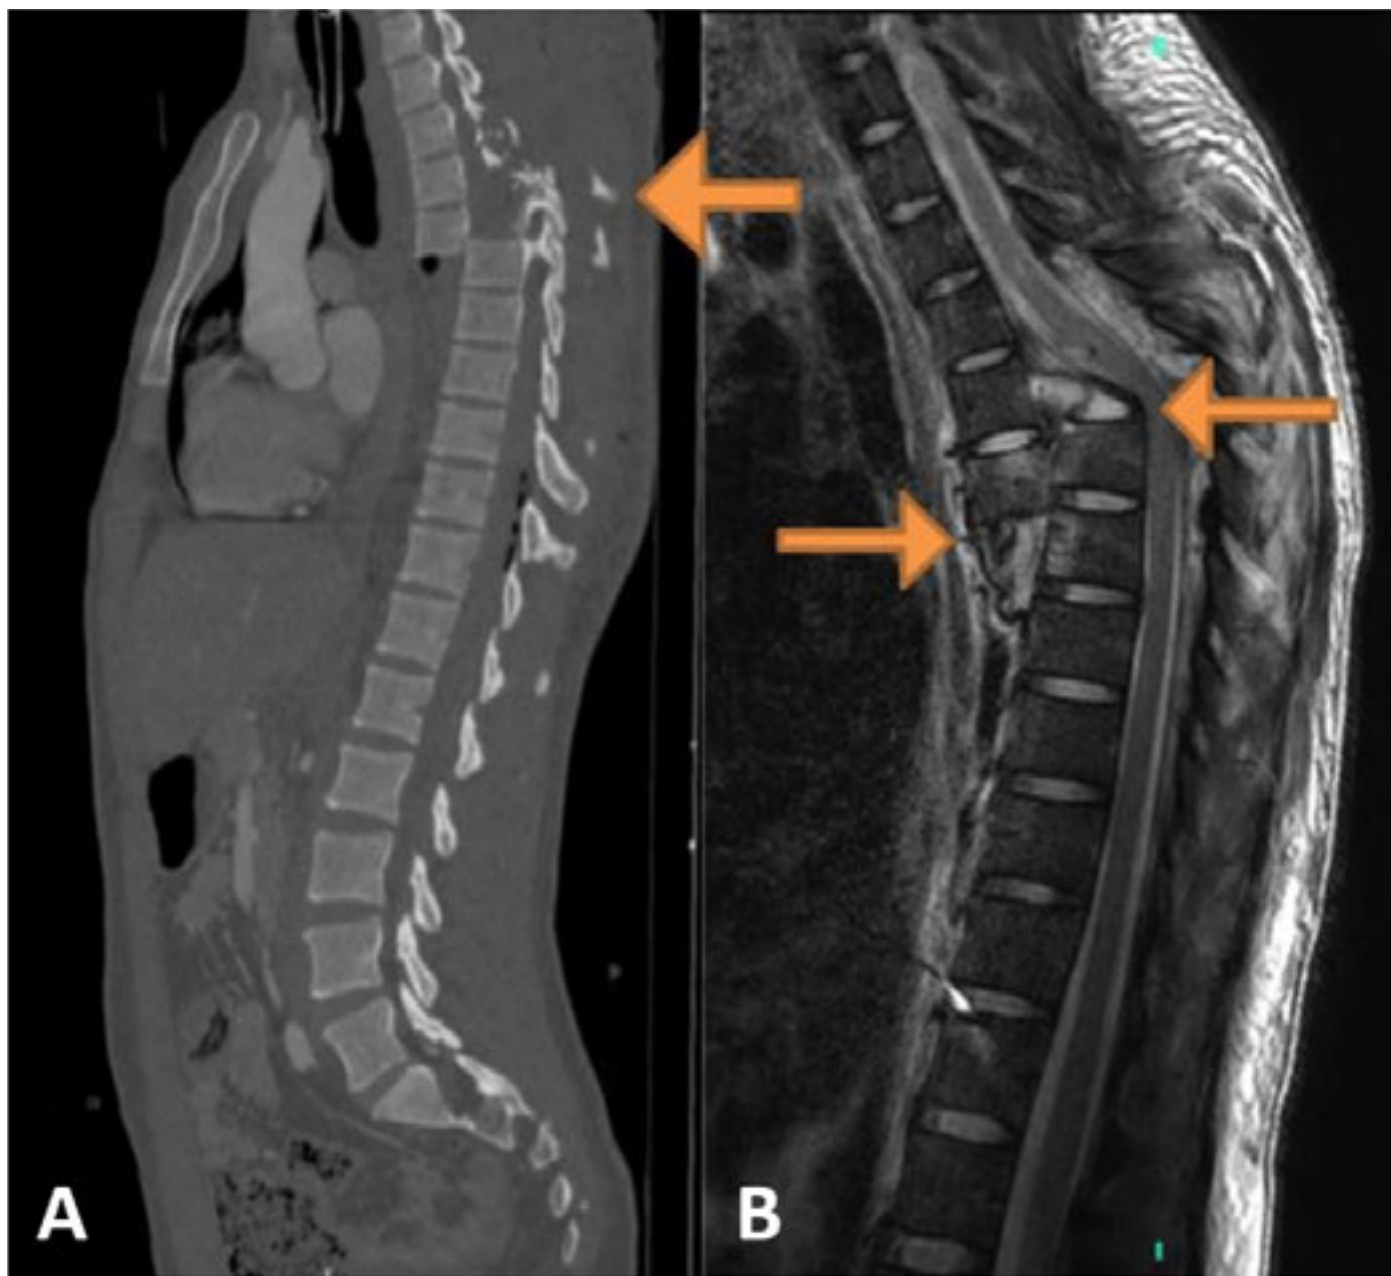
Preoperative imaging: Computed Tomography (CT) and sagittal T2-weighted MRI demonstrating T5-T6 spondyloptosis.
